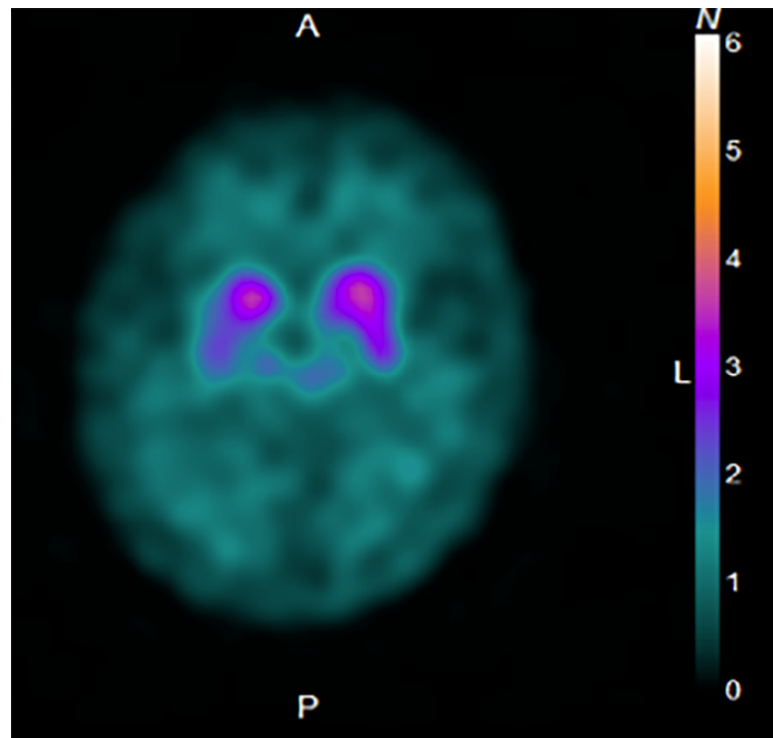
^{123}I -ioflupane SPECT (dopamine transporter scan) showed reduced striatal uptake.
